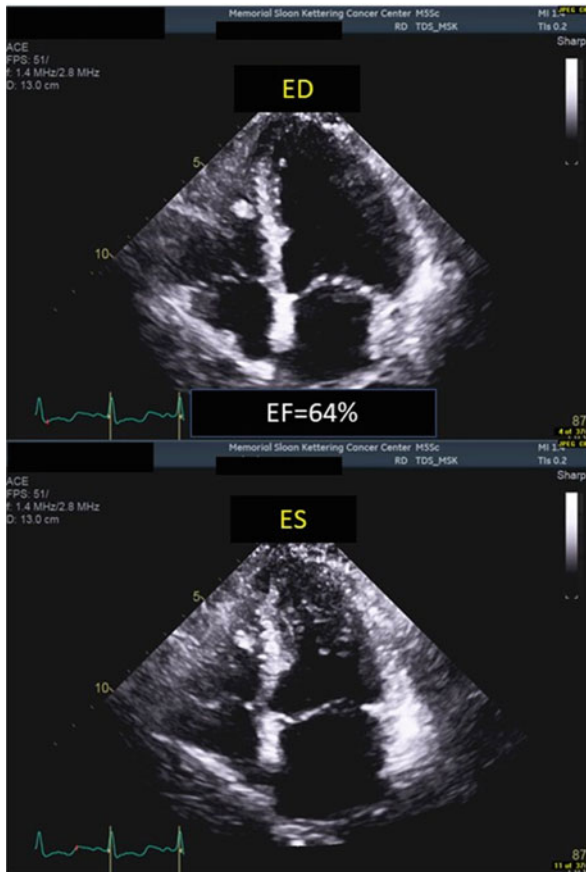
Still frame ED and ES images from the echocardiogram after treatment with RCDOP which resulted in marked improvement in the patient's respiratory distress. EF = 64%. Chest X-ray shows
